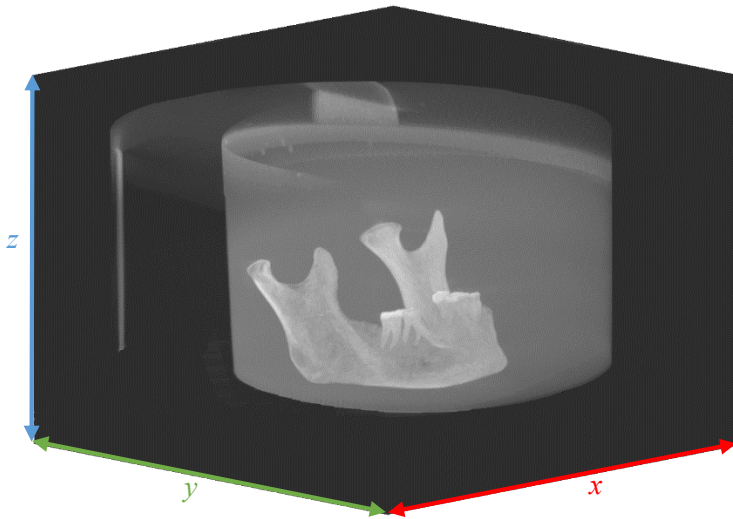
Reconstructed CBCT dataset with the scanned mandible placed in a plastic container and filled with distilled water
